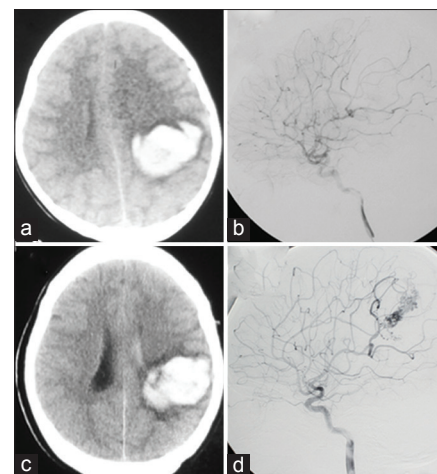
(a) CT scan at admission showing an intracerebral hematoma in the left frontoparietal region. (b) A left internal carotid angiogram at admission showing no abnormal findings that could explain the hemorrhage. (c) A CT scan captured 8 years after the initial episode showing hematoma recurrence at the same location as that when the patient first presented with disturbed consciousness. (d) A left internal carotid angiogram showing a diffuse AVM
